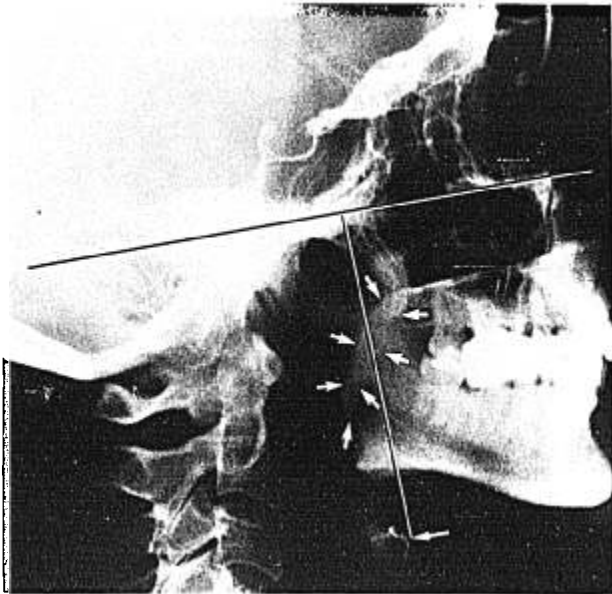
Lateral x-ray of adult male control. The extent of the soft palate is delineated by the short arrows. Note the position of the Frankfurt horizontal (FH) plane and the relationship between the FH and the hyoid bone (long arrow in figure).
